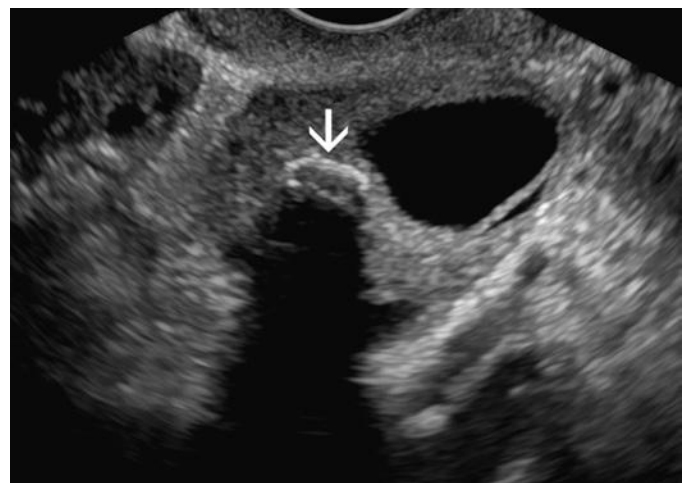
Ovarian calcification. A 9-mm calcification (*arrow*), with posterior acoustic shadowing, is shown within an otherwise normal-appearing ovary. Such calcifications are generally of no clinical significance, but may be followed sonographically.
